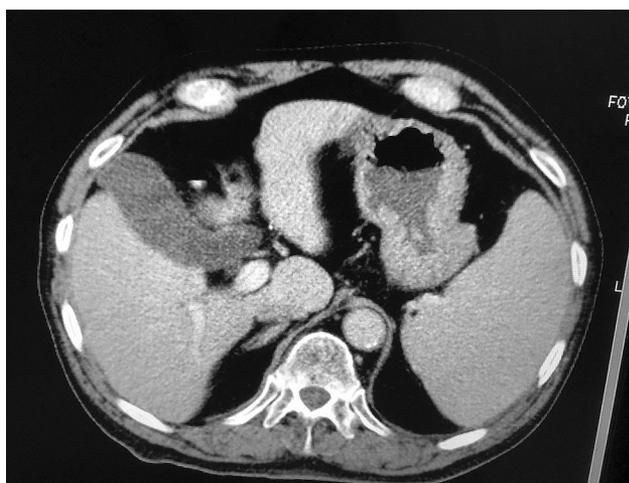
Axial CT shows a normal gallbladder fundus indented and flattened by the anterior abdominal wall.
